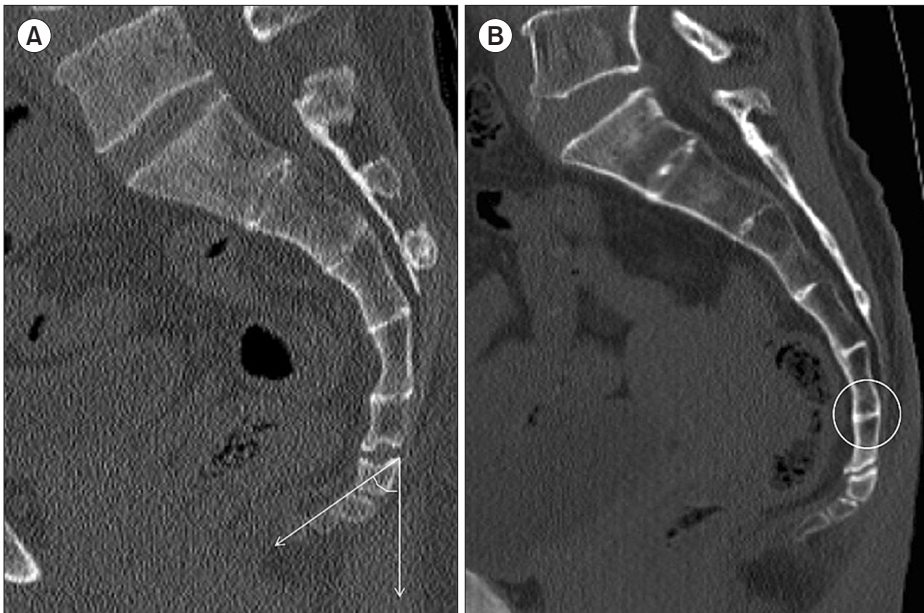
Computed tomography images showing morphology of the sacrococcygeal region. (A) The coccygeal type is classified according to the angle between a line from the center of the first coccygeal segment to the tip of the last coccygeal segment and a vertical line. (B) Sacrococcygeal fusion (circle) is noted.
